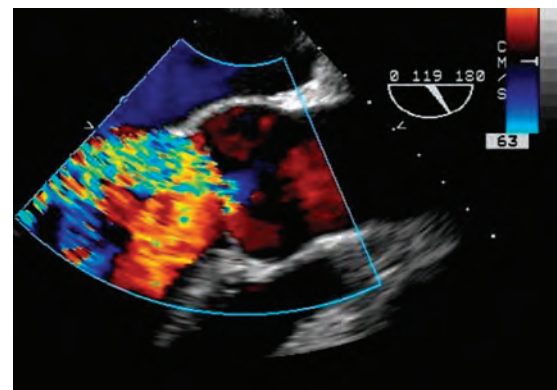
Midesophageal long-axis view of the aortic valve (imaging angle of 119 degrees). Color-flow Doppler imaging reveals severe aortic regurgitation. The jet of aortic regurgitation almost fills the entire left ventricular outflow tract. It is partly directed posteriorly toward the anterior mitral leaflet. This posterior eccentric flow may be caused by prolapse of the anterior aortic cusp or a perforation in the posterior cusp.
